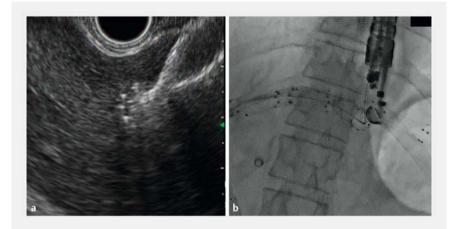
a Endoscopic ultrasound-guided hepaticogastrostomy: 8-mm×8-cm fully covered self-expanding metal stents (FCSEMSs) were placed, but the stent on the gastric side migrated into the abdominal cavity. b, c Endoscopic ultrasound (EUS) showed complete migration into the abdominal cavity.
